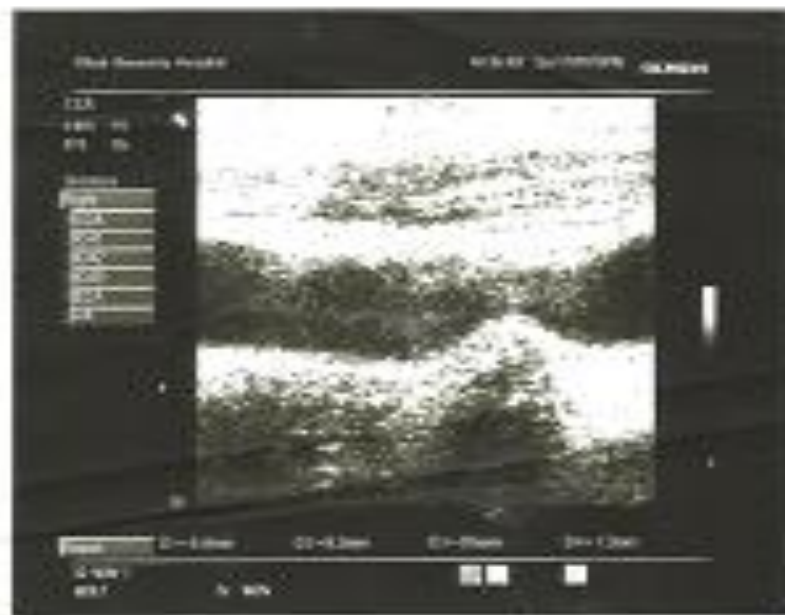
Rt CCA-male-57 years diabetic patient with normal Doppler parameter.
